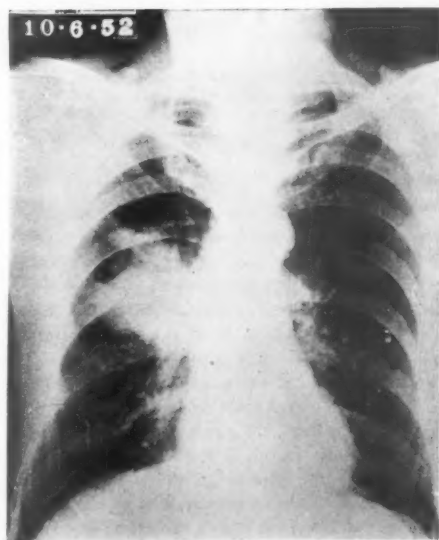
This opacity, in the base of the right upper lobe, was found in a mass X-ray survey. At this time, the patient was symptomless. (Case 2)
